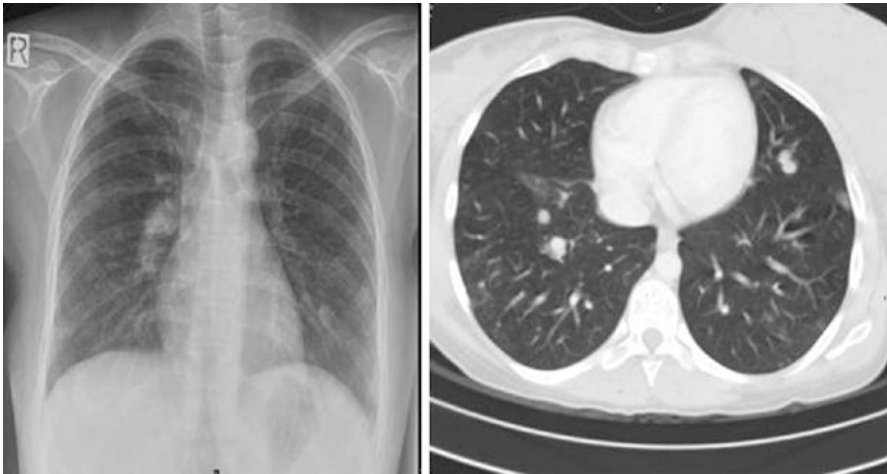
Plain chest radiograph and CT thorax in lung window of a patient with choriocarcinoma showing multiple pulmonary metastases on CT
